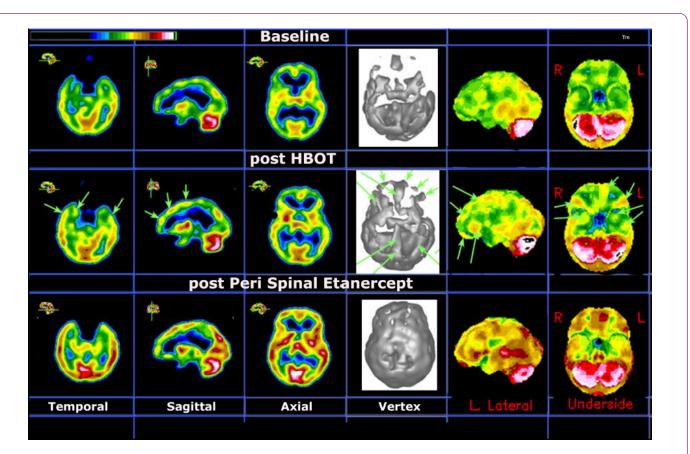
Single-photon emission computed tomography (SPECT) imaging results. The color code indicates the level of blood flow, which in turn is proportional to the metabolism level. This enables the detection of hyper or hypo functioning areas: from lowest levels (blue hues) to highest levels (white and black surrounded by white). The black and white display is a volumetric rendition at a standardized threshold level for all three studies. The baseline SPECT shows extensive areas of marked hemispheric underperfusion (top row). There was progressive improvement after hyperbaric oxygen treatment (HBOT) in multiple locations, as highlighted by the green arrows (middle row). The final scan, completed after the series injections of perispinal etanercept (PSE) (bottom row), shows overall marked improvement (increased perfusion) in the whole cortex including in the orbito-frontal and apico-mesial temporal areas, bilaterally. There is also increased relative perfusion in the putamen bilaterally and in the mid thalamus. In addition there are now several localized areas of hyperperfusion in each hemisphere as well as in the posterior cingulate/precuneus area.
